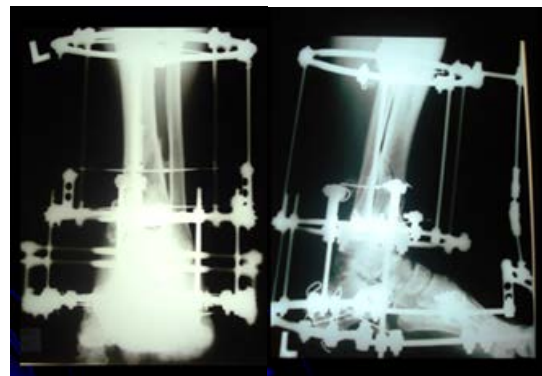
Postoperative AP and LL x-ray of a distal tibial fracture with Ilizarov apparatus and calcaneal semi-ring
